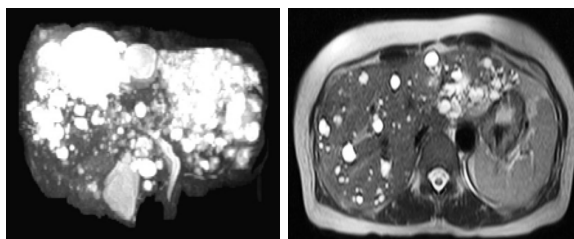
T2W MRI liver showing multiple cystic lesions on both lobes
